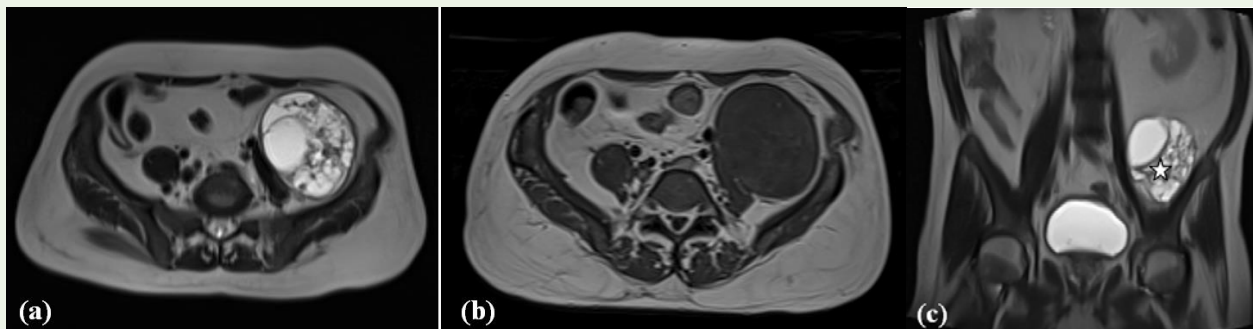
MRI on T2-weighted image (a) and T1-weighted image (b) shows a well-defined, round to oval, retroperitoneal lesion encapsulated solid-cystic lesion with T2 hypointense thick internal septations (asterisk) in the left iliac fossa and shows mass effect by displacing left psoas major muscle, left internal and external iliac vessels medially (b). The lesion is noted between the left iliacus and psoas muscle (c).
